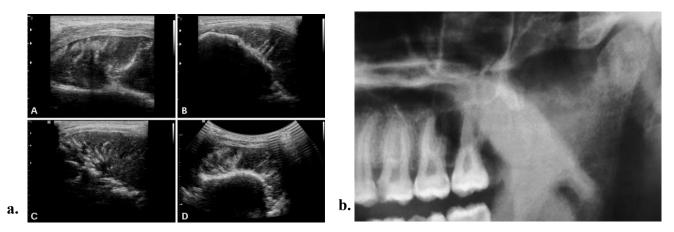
a. Ultrasonographic image shows soft tissue component of the lesion with well-defined hypo-echogenic pattern and hard tissue component of the lesion with ill-defined hyper-echoic pattern. B, C, and D. b. Cropped panoramic radiograph reveals destruction of cortical bone in the region of left sigmoid notch and ascending ramus. Irregularity of cortical border in the region is observed.
